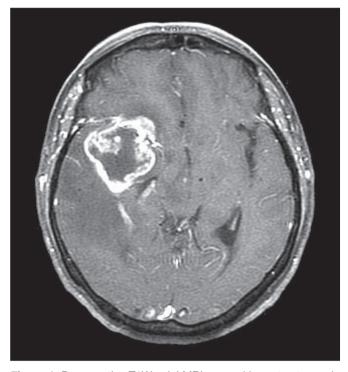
Preoperative T1W axial MRI scan with contrast reveals a poorly marginated, diffusely infiltrating necrotic mass lesion and midline shift.
